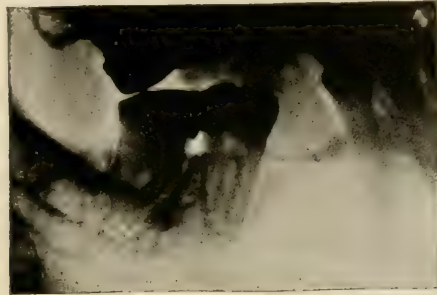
Very small abscess at apices of roots of lower third molar; appearance similar to that of large periapical space.
